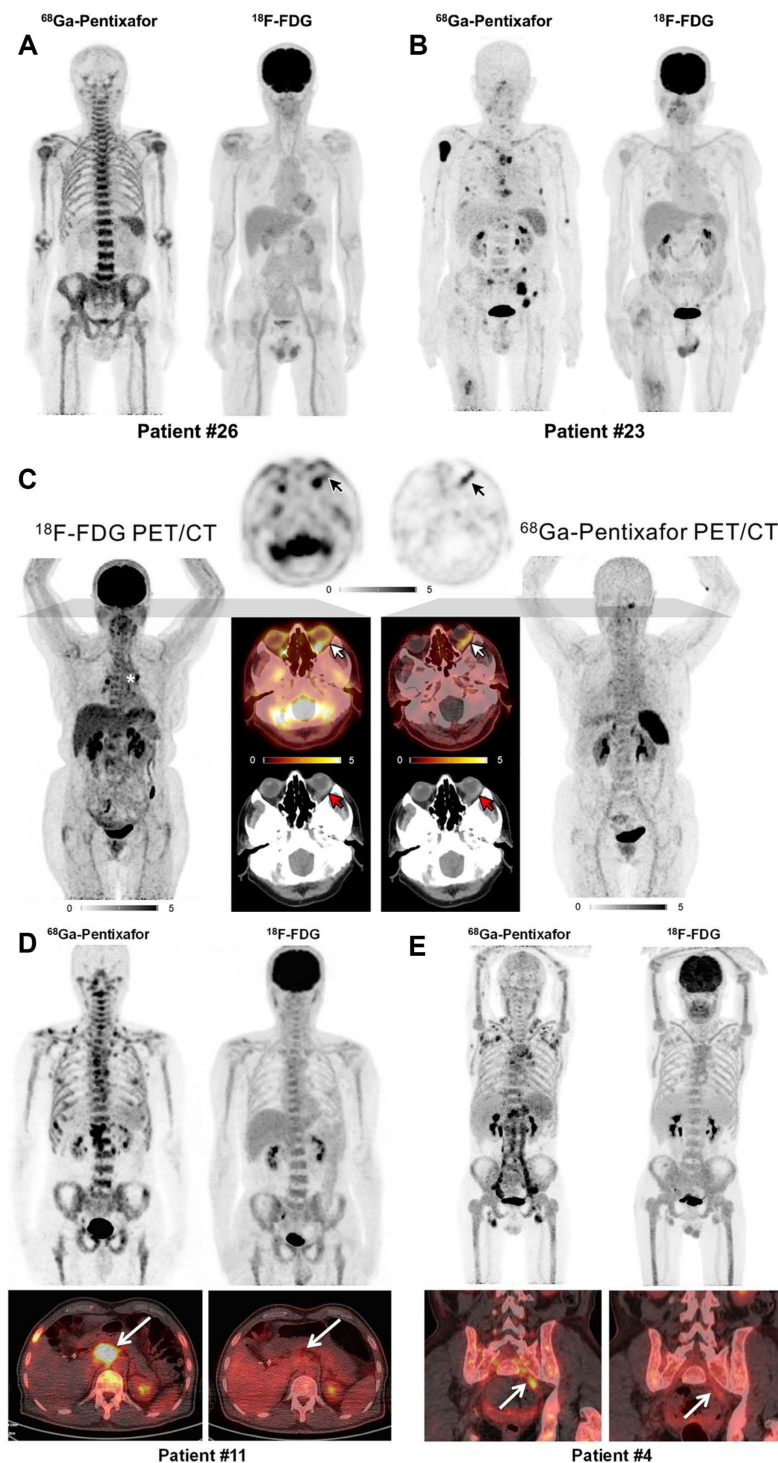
Clinical application of [^{68}Ga]Pentixafor in MM, MZL, and WM/LPL. (A) Patient #26 with IgA-λ MM demonstrating diffuse bone marrow infiltration pattern. Intense [^{68}Ga]Pentixafor uptake in bone marrow with negative [^{18}F]FDG avidity. (B) Patient #23 with IgA-λ MM. Multiple bone marrow lesions detected by [^{68}Ga]Pentixafor PET, while [^{18}F]FDG uptake remained negative. Adapted with permission from [60], copyright © 2020, Springer Nature. (C) Maximum-intensity-projection images of [^{18}F]FDG and [^{68}Ga]Pentixafor PET in a patient with EMZL. Central axial sections demonstrate orbital lymphoma manifestation with discordant tracer uptake ([^{18}F]FDG-negative, CXCR4-positive), annotated with white (PET/CT), black (PET), and red (CT) arrows. Asterisk indicates intense focal uptake in two hilar lymph nodes; biopsy confirmed sarcoidosis, not MZL. Adapted with permission from [68], copyright © 2021, Society of Nuclear Medicine and Molecular Imaging. (D) Patient 11 with WM (IgM λ), ISS-WM score 2 (indeterminate risk). [^{68}Ga]Pentixafor imaging demonstrated intense bone marrow uptake with multifocal lesions and CXCR4-positive lymph nodes (arrows). [^{18}F]FDG activity (score 4) showed homogeneous bone marrow distribution without nodal avidity (arrows). (E) Patient 4 with WM (IgM κ) and Bing-Neel syndrome, ISS-WM score 2 (indeterminate risk). Multiple CXCR4-positive lymph nodes were detected in cervical, axillary, hepatoduodenal, retroperitoneal, iliac, and inguinal regions, most undetected by [^{18}F]FDG PET. The involved left iliac nerve root (arrow) was CXCR4-positive but [^{18}F]FDG-negative. Adapted with permission from [55], copyright © 2019, Society of Nuclear Medicine and Molecular Imaging.
